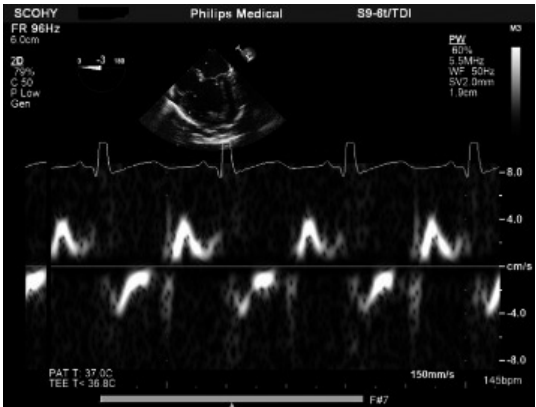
Pulsed-wave Tissue Doppler Imaging at the septal site of mitral valve annulus in a 2.6 kg neonate.
